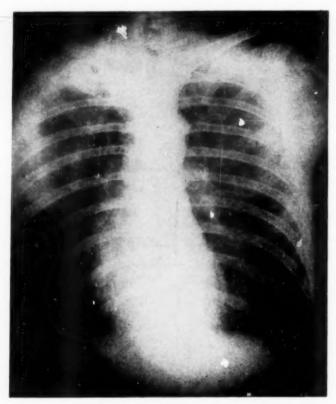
Chest roentgenogram on the day after attack. Note the dilated heart as compared with figure 5. The lungs were interpreted by the roentgenologist as clear.
